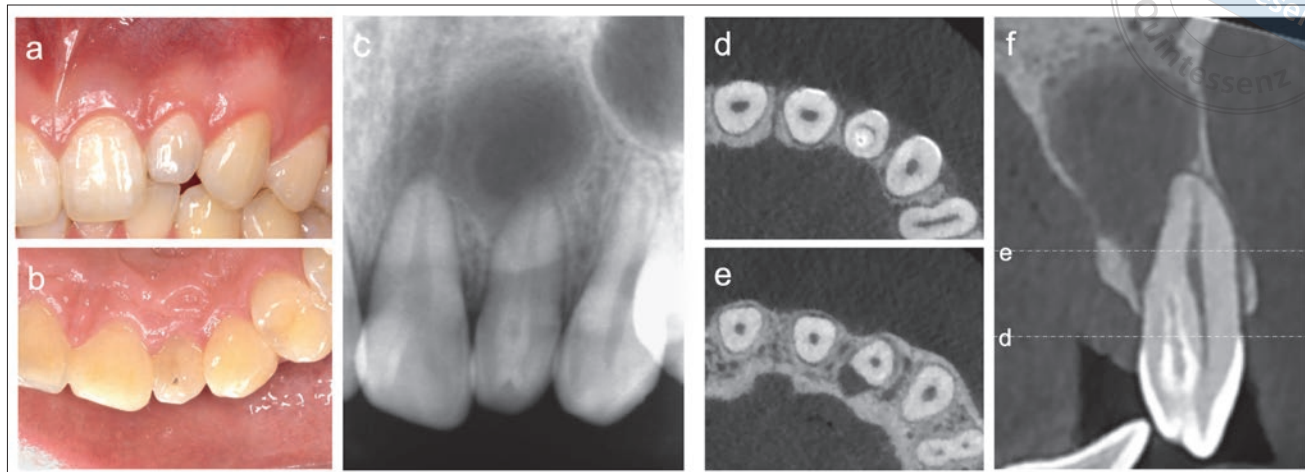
Labial view of the preoperative intraoral examination of the maxillary left lateral incisor with Oehlers type IIIA dens invaginatus (a). The palatal view shows a pit associated with caries on the palatal side of the maxillary left lateral incisor (b). The preoperative radiograph shows a hollow strip-shaped high-density invagination that starts from the crown and propagates into the middle third of the root, inside the maxillary left lateral incisor. A large apical radiolucency is shown around the apex of this tooth (c). Axial sections of CBCT images (d and e). The sagittal section of the CBCT images shows an Oehlers type IIIA dens invaginatus inside the maxillary left lateral incisor (f). The dashed lines in (f) indicate the cutting sections of (d and e).
